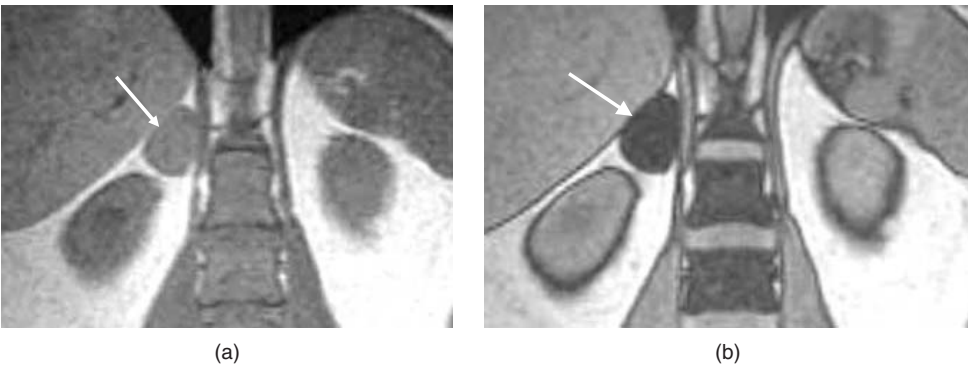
Adrenal adenoma. Coronal in-phase (a) and out-of-phase (b) MR images show an adrenal mass (arrow) which exhibits a typical decrease in signal intensity on the out-of-phase image.
